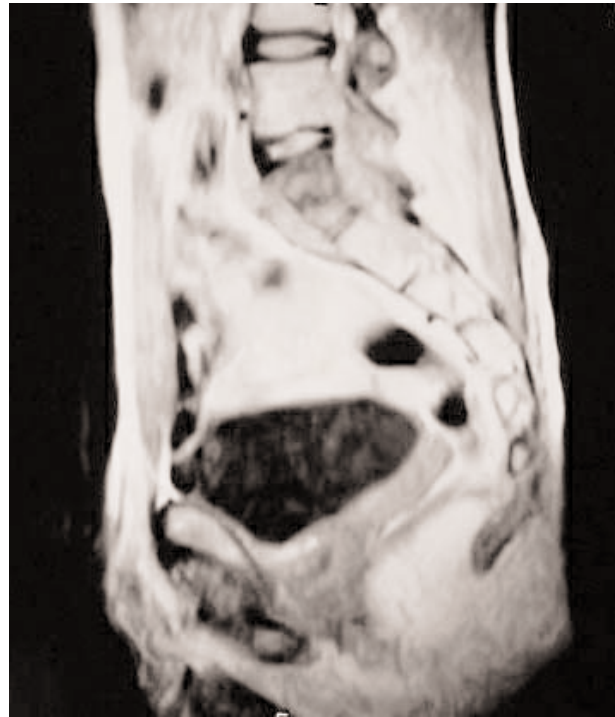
MRI shows soft tissue lesion inflicting vertebral destruction in the presacral region (L5-S2).
